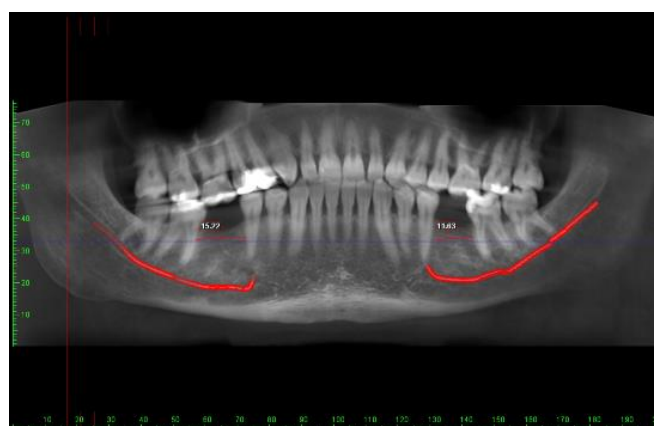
Nerve tracing with estimation of the available mesio-distal distance from a reconstructed 2D image from the CBCT scan
